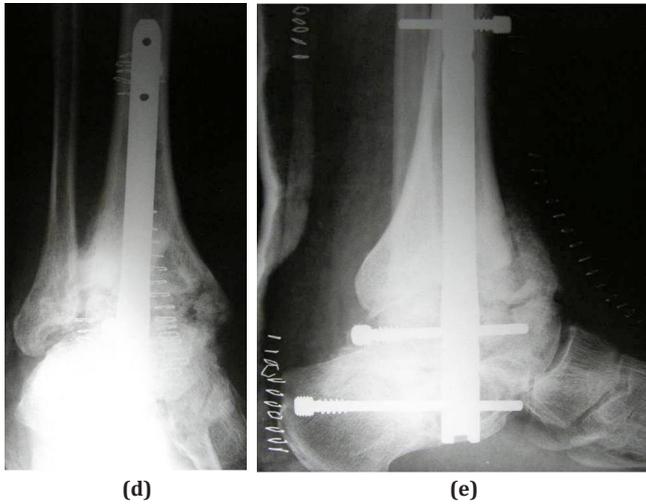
d, e. (d) immediate anteroposterior postoperative image; (e) immediate postoperative lateral radiograph.
